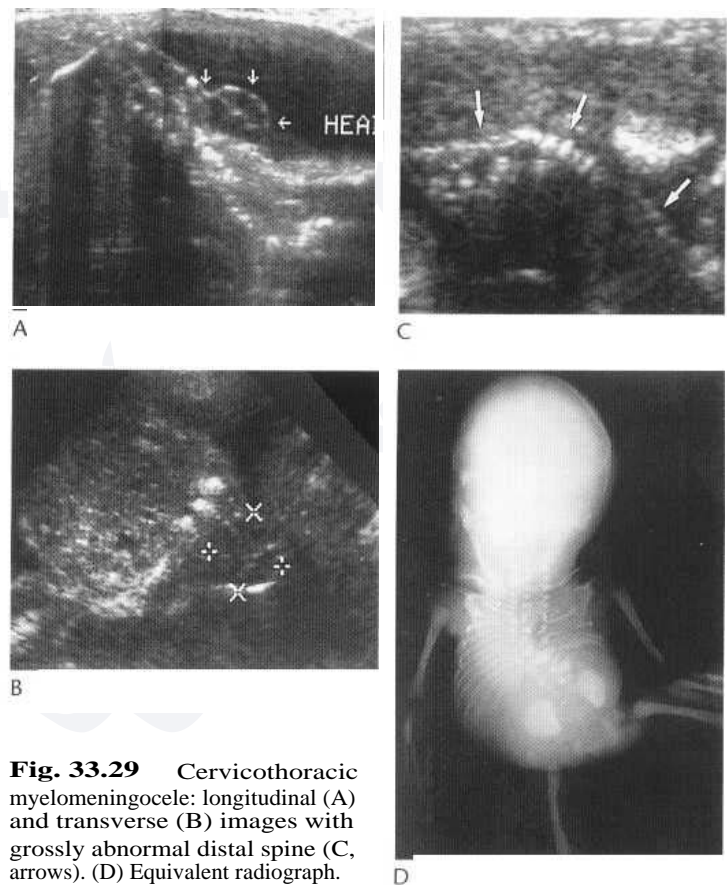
Cervicothoracic myelomeningocele: longitudinal (A) and transverse (B) images with grossly abnormal distal spine (C, arrows). (D) Equivalent radiograph.
